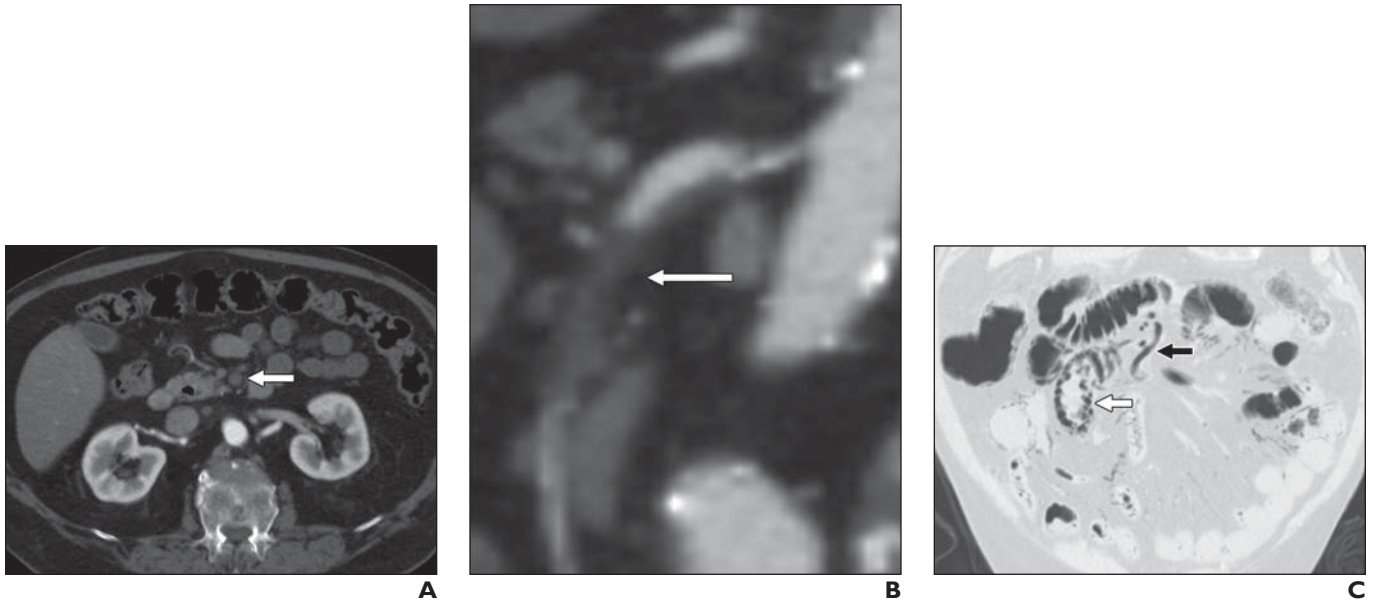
67-year-old patient with acute abdominal pain who was diagnosed with embolic mesenteric ischemia. A and B, Contrast-enhanced axial (A) and sagittal (B) CT images show embolic occlusion (*arrows*) of superior mesenteric artery. C, Coronal CT image shows extensive pneumatosis (*white arrow*) and mesenteric venous gas (*black arrow*).
